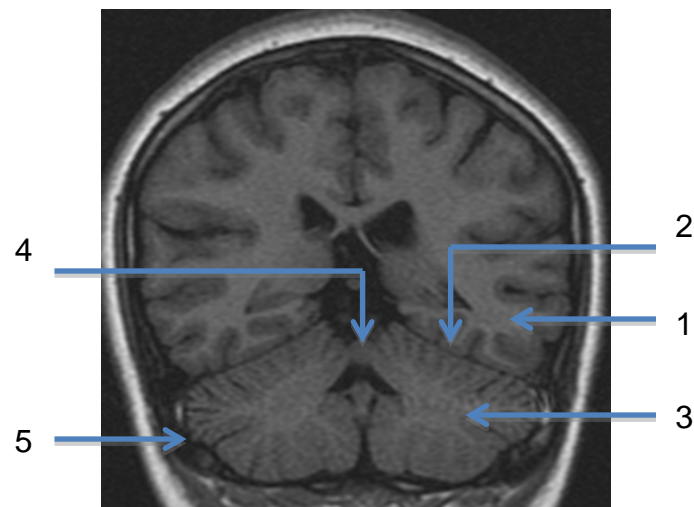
MRI image axial cut at level of cerebellar vermis
